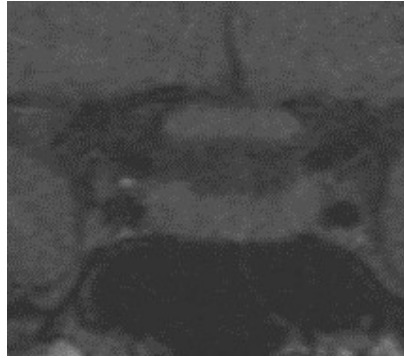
(Pre-Contrast): The pre-contrast image of the pituitary gland shows a noticeable decrease in size compared to the initial MRI.
